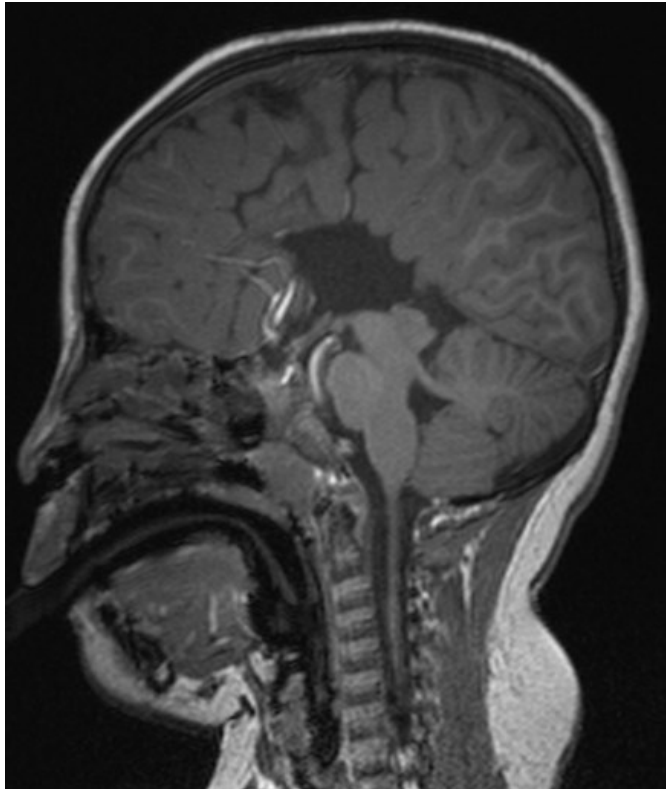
MRI scan, sagittal T1 sequence show the corpus callosum with completely absent-agenesis of the corpus callosum
